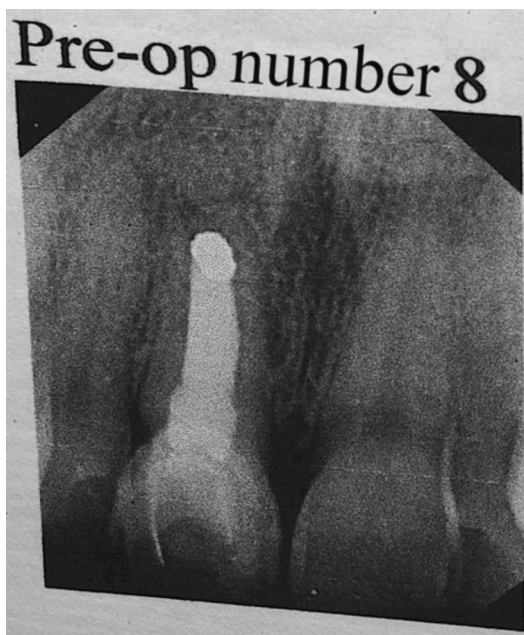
Initial radiograph of patient.
